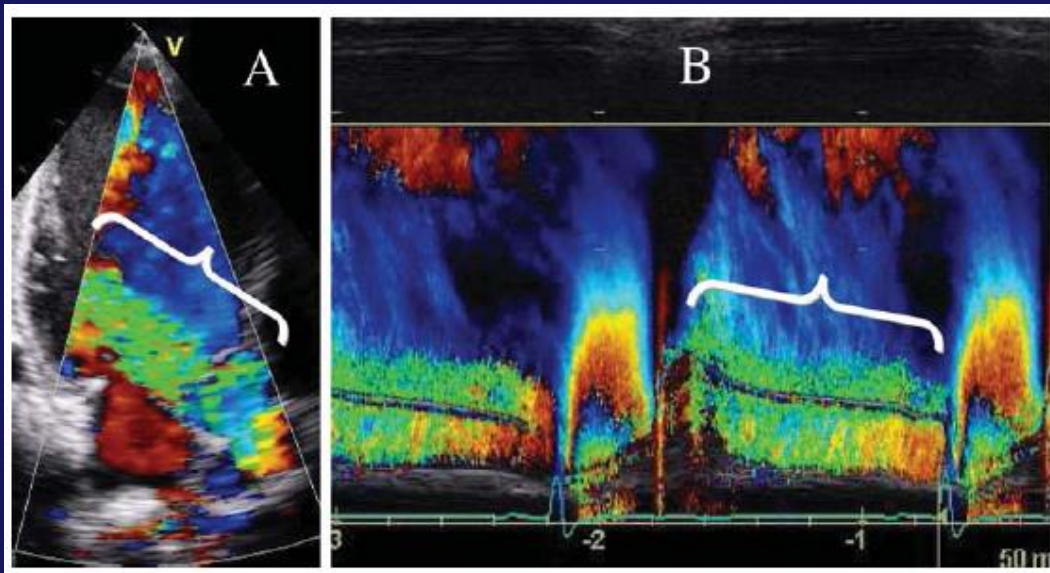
(A) Colour Doppler showing a severe aortic regurgitation; (B) colour-coded M-mode depicting the time dependency of flow signal during the heart cycle.
